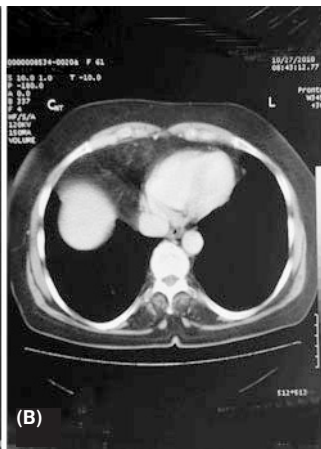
MR imaging (A), CT imaging (B) demonstrated diaphragmatic hernia and hernia sac.
